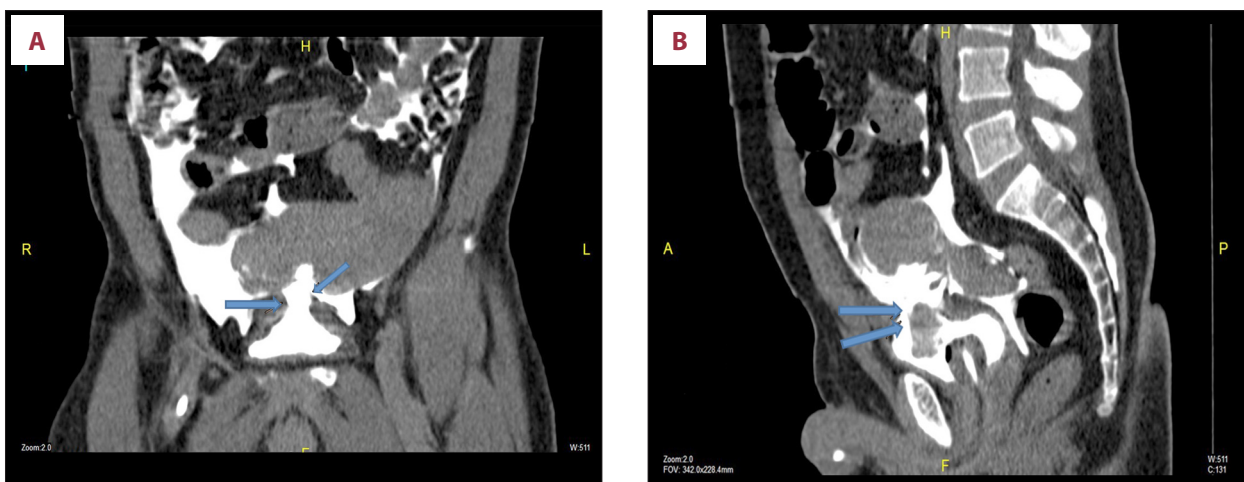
(A, B) CT cystogram showing the intraperitoneal fluid collection and urinary bladder rupture at the dome.
